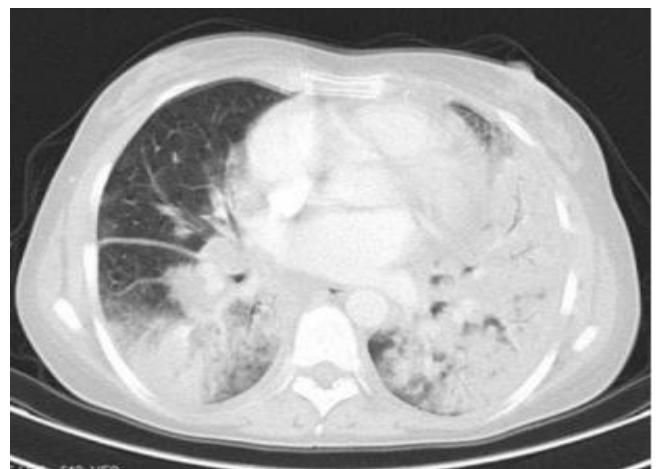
CT image of the patient.
